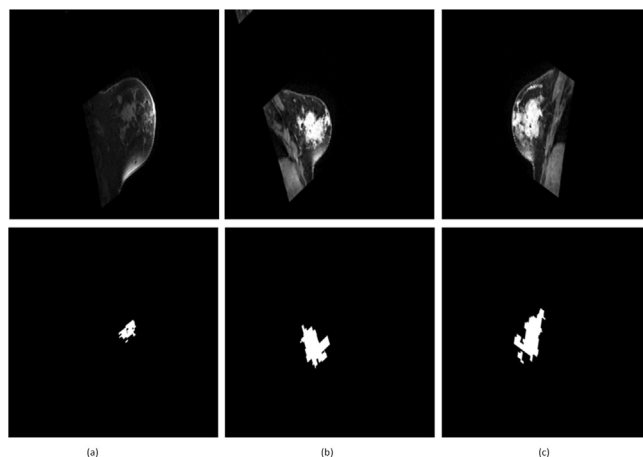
RIDER breast MRI tumor images(1st row) in gray scale with their corresponding binary masks(2nd row).
